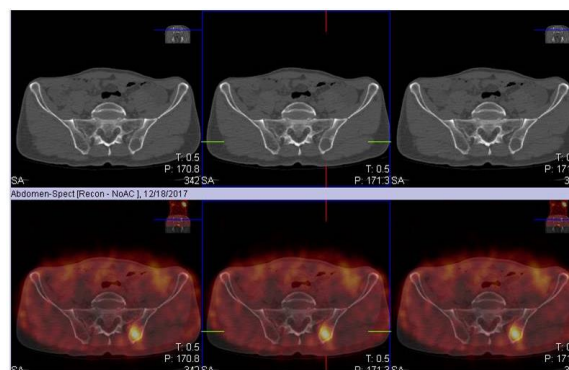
SPECT/CT acquisition confined the tracer uptake to the left iliac ala.
